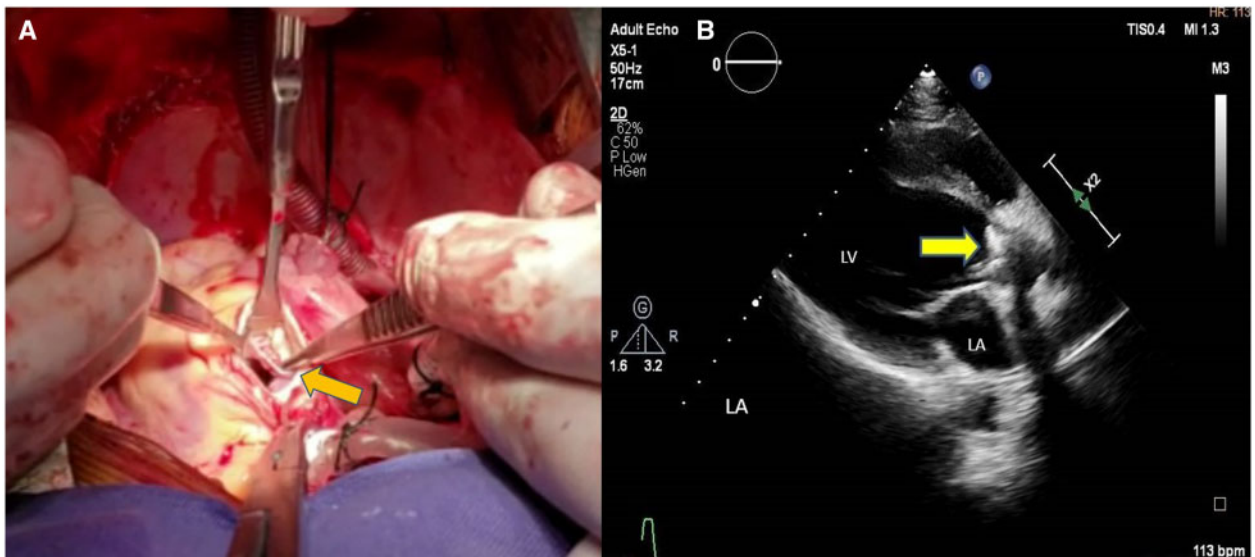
(A) Intraoperative picture showing prolapsed right aortic cusp. (B) Post-operative echocardiogram after 1 month showing well-seated prosthetic aortic valve.
